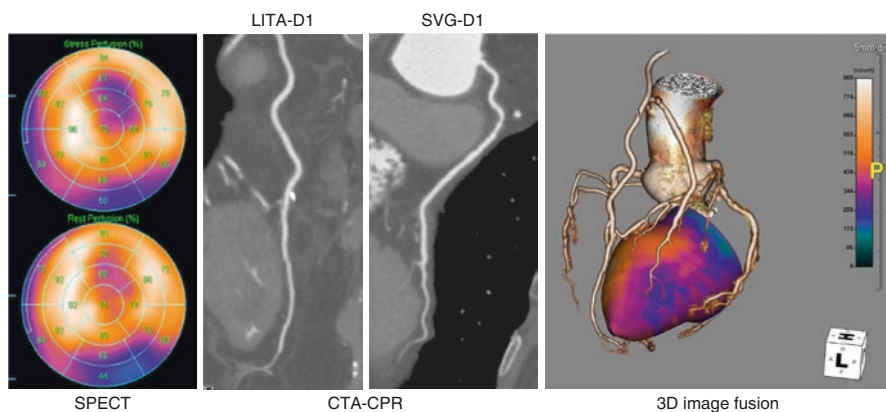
3D fusion image of CTA and SPECT in a patient post status of bypass surgery is shown. SPECT shows regional ischemia in mid-anterolateral wall, while CTA shows no significant stenosis or obstruction in bypass grafts. Image fusion demonstrates the ischemia is corresponding for distal site of native diagonal branches
